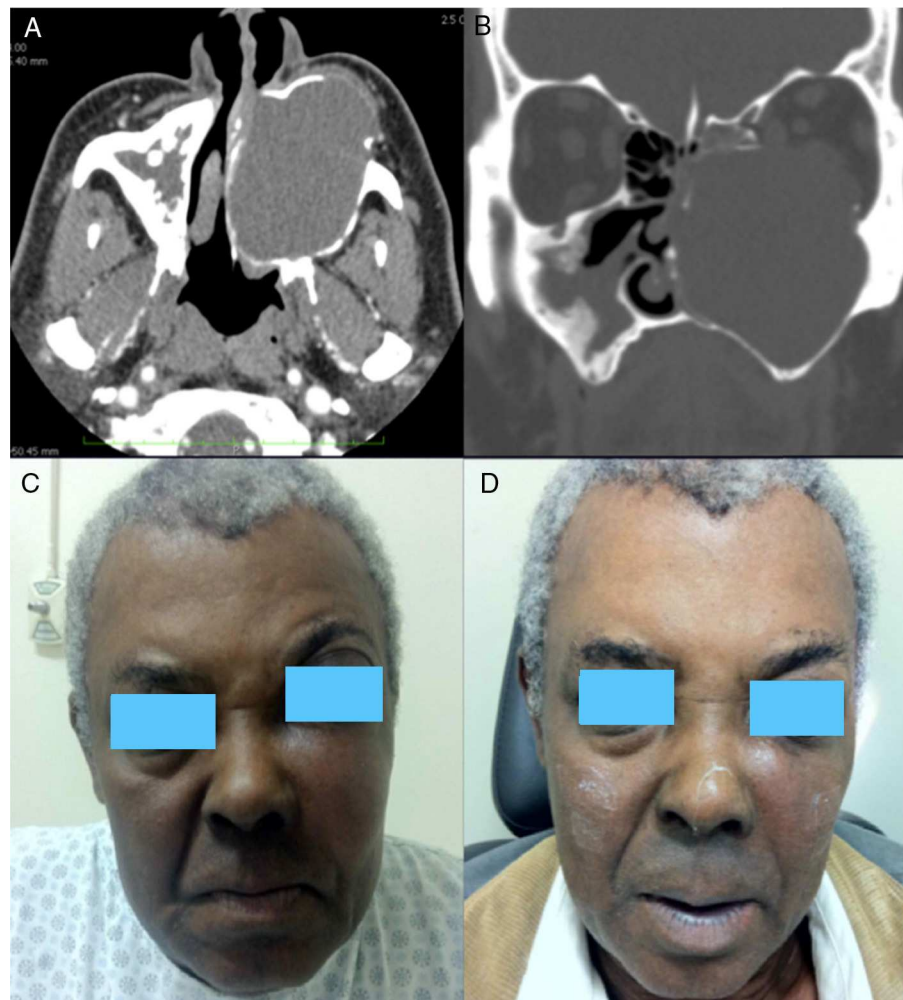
(A) Computed tomography (CT) (axial section), showing an expansive lesion occupying the entire left maxillary sinus and promoting remodeling of bone limits. (B) CT (coronal section), showing an extension of the lesion to the orbital cone. (C) Preoperative picture showing bulging of the malar area and proptosis (left side). (D) Postoperative photography showing a clear improvement of bulging and proptosis.
